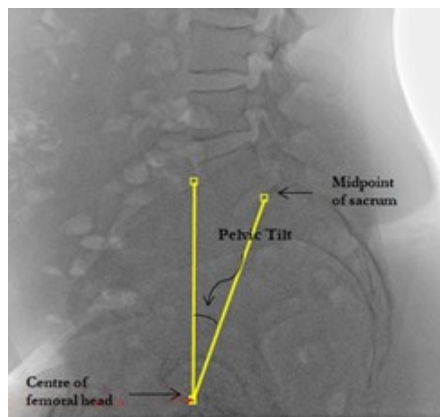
X-ray of lumbosacral spine (lateral view) demonstrating calculation of “pelvic tilt”. Source: Figure by authors.
